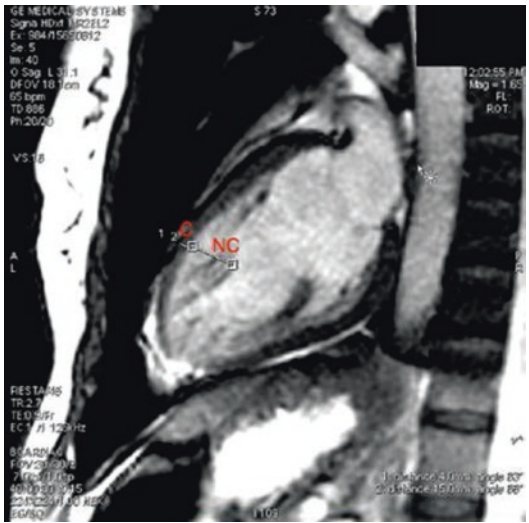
Sagittal section of the LV on MRI of a patient with LVNC. Prominent trabeculations are seen on the mid-anterior wall of the LV with two distinct layers. The ratio of non-compacted (NC) to compacted (C) ratio exceeded 2.3 in all apical segments and mid-anterior wall
